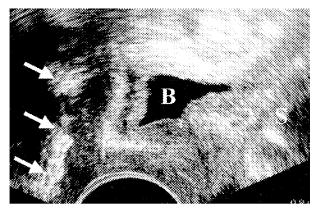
Introital ultrasound image (midsagittal view) showing thickening of the hyperechoic polypropylene mesh (arrows) 6 weeks after transischioanal mesh interposition for rectocele repair. B, bladder; S, symphysis.
